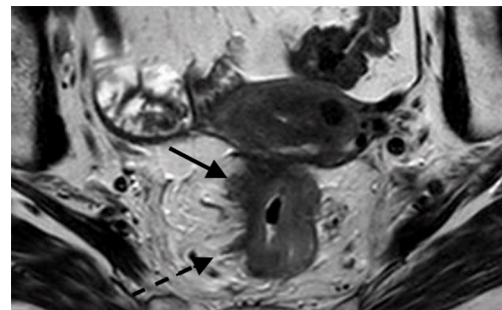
Rectal MRI in the axial plane shows tumour extension (solid arrow) beyond the muscularis propria for a length of 7 mm (mrT3c tumour), and presence of mrEMVI (dashed arrow). Neoadjuvant chemoradiotherapy is indicated.
